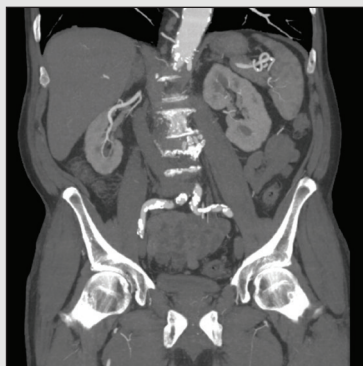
Preoperative CTA showing severe calcification of bilateral iliac arteries.
